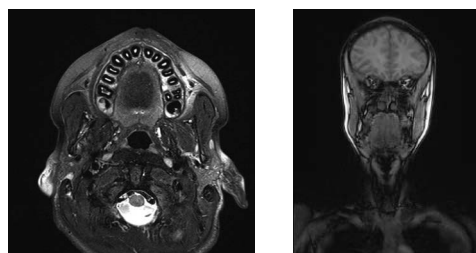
MRI scans in 6-months follow-up
